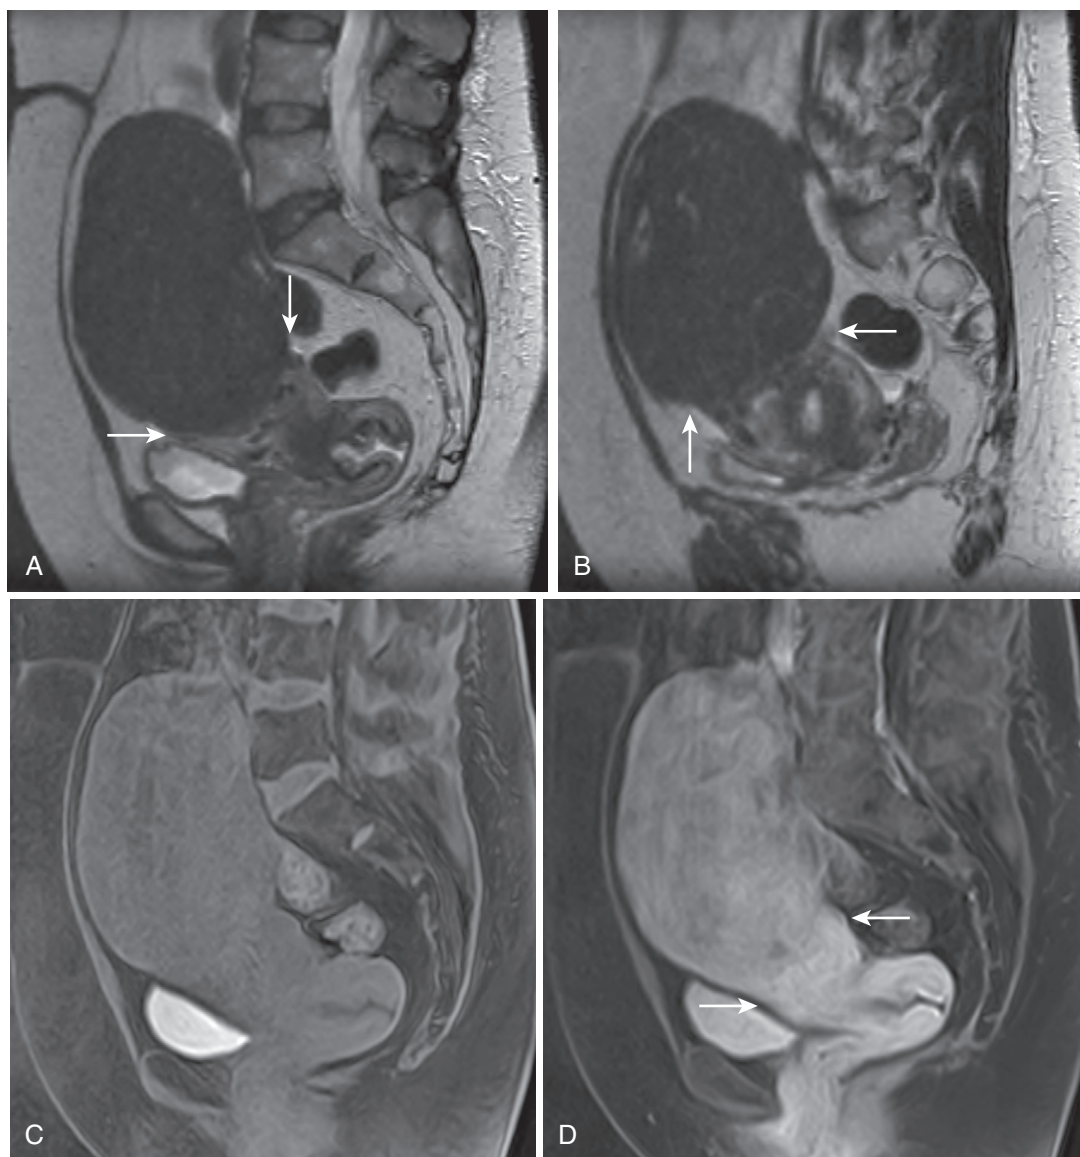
Subserosal fibroid. Sagittal T2-weighted (A and B) and T1-weighted fat-saturated gradient echo unenhanced (C) and enhanced (D) images depict myometrium encircling the caudal aspect of a large subserosal pedunculated fibroid (arrows in A, B, and D).
